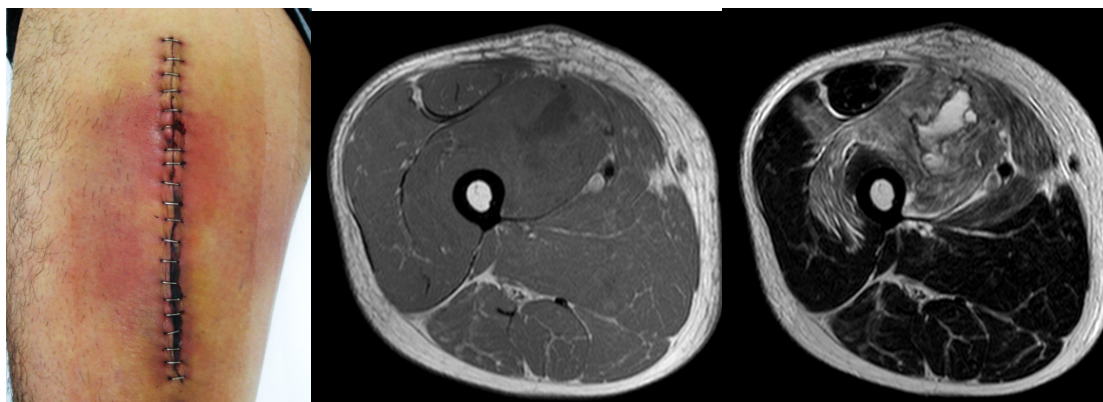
Magnetic resonance images and photograph of the right thigh after tumor resection. A: Photograph of the surgical wound. Erythema and local increase in temperature were observed around the surgical site. B: T1-weighted axial image. C: T2-weighted axial image. MRI findings were suggestive of an infected hematoma and extensive inflammation in the muscle.
